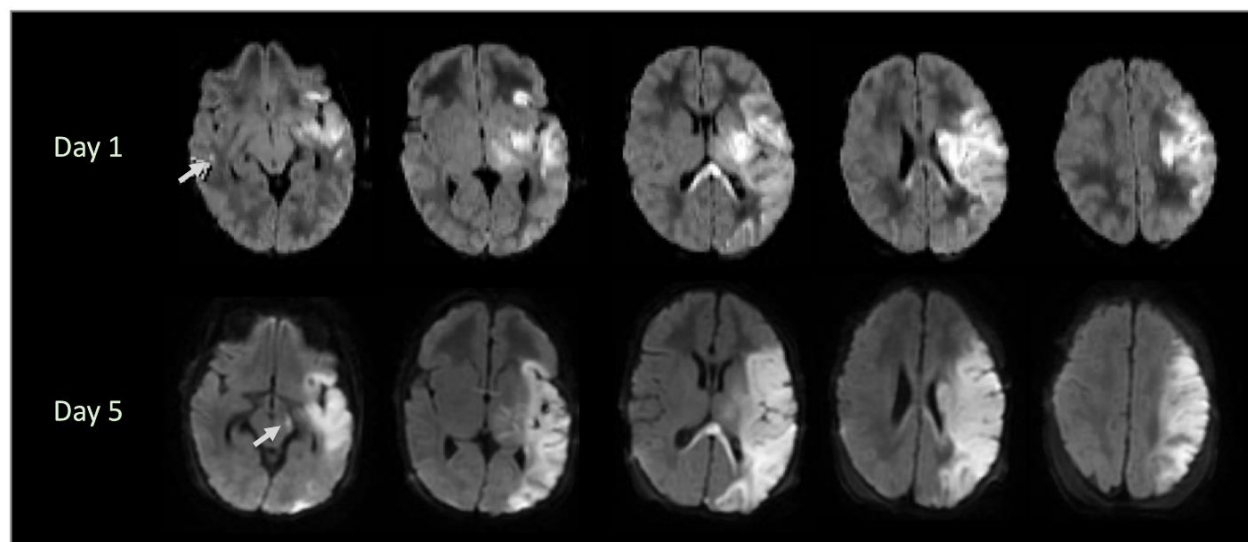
Evolution of NAIS injury. Diffusion MRI on day 1 shows a recent left MCA NAIS. Note small infarct in right hemisphere confirming proximal embolism (arrow). Repeat MRI at 5 days shows marked increase in stroke size (see left temporal lobe, 2nd images from left for example). Corticospinal preWallerian degeneration (diaschisis) is now evident (arrow).
